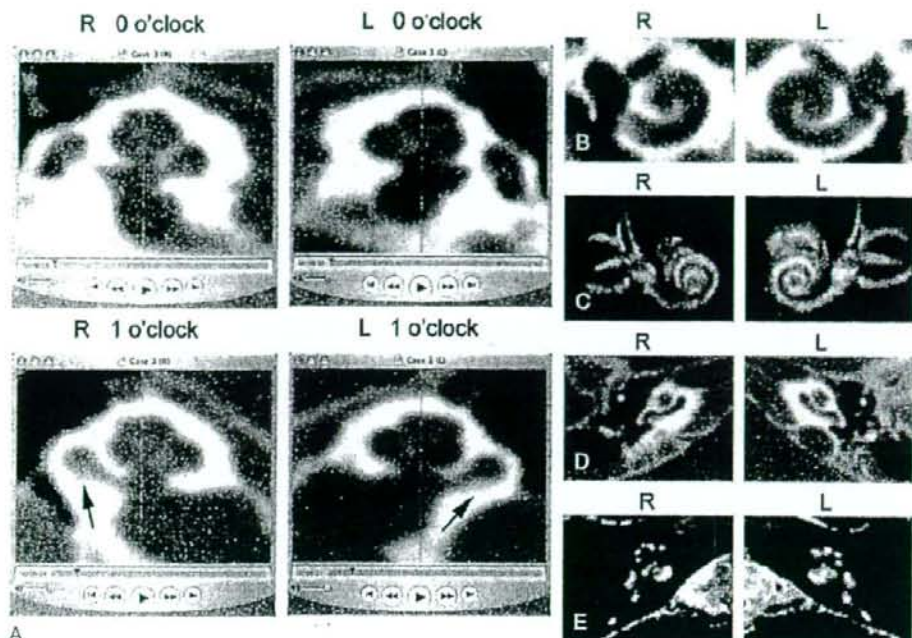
Imaging of Patient 1. *A*, Computed tomographic movies of right (*R*) and left (*L*) cochleas (see supplemental online videos). The arrows indicate ossification. *B*, Basal turn planes. *C*, Reconstructed MR images (T2-weighted). *D*, Conventional axial CT images for reference. *E*, Conventional axial T2-weighted MR images for reference. The basal turn planes showed partial ossification in the inferior segment of the basal turn in the bilateral cochleas, but a bilateral difference was not clear. Computed tomographic movie showed ossification between 1 and 4 o'clock from the RWN (inferior segment up to the ascending turn) in the basal turn of the right cochlea, and the ossification was most severe approximately 2 o'clock from the RWN (the same in all following indications of clockwise positions). Ossification was also apparent in the right middle turn starting from 6 o'clock. The reconstructed MR image (T2) on the right showed fluid in the intracochlear spaces spared from ossification, indicating little soft tissue formation. On the left, the CT movie demonstrated slight ossification between 1 and 3 o'clock in the basal turn and severe ossification starting from 9 o'clock in the basal turn extending to the middle turn. The reconstructed MR image showed fluid in the intracochlear spaces spared from ossification.
